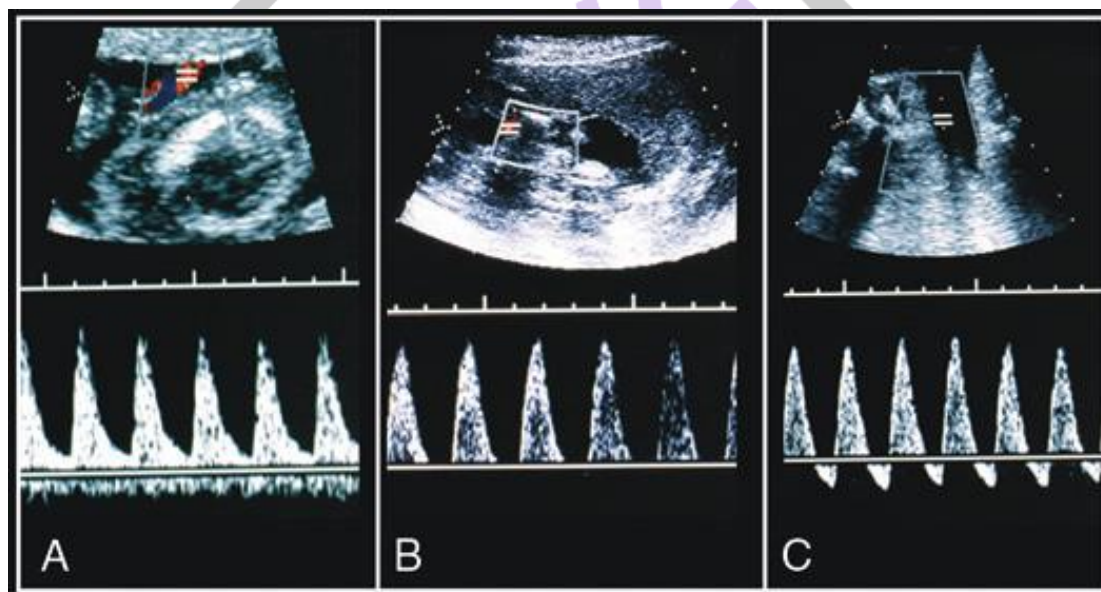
Abnormal umbilical artery Doppler waveforms; decreased end-diastolic velocity (A), absent end-diastolic velocity (B), reversed end-diastolic velocity (C).
